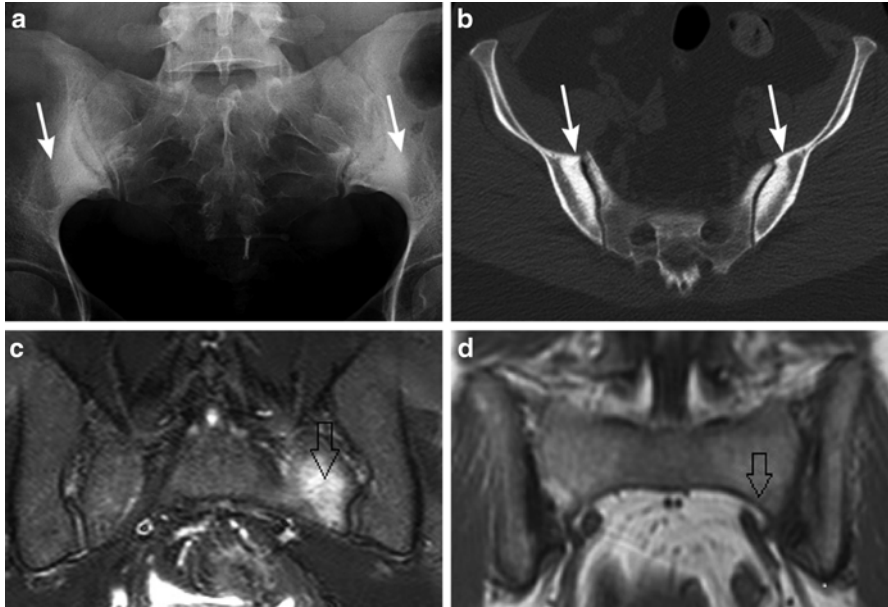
A 36-year-old woman presenting with left back pain 3 months after fifth delivery. She has a history of similar pain after other deliveries. Images taken at 3 months postpartum demonstrate the radiography (a) and CT (b) appearance of osteitis condensans ilii, an older descriptive radiographic term referring to bilateral, symmetrical, dense bone formation (arrows) in a triangular pattern along the anterior-inferior iliac side of the SI joint. Osteitis condensans ilii is associated with previous and recent pregnancies. On the MRI of the sacroiliac joints with (c) axial T2 fat saturated sequence there is an unsuspected small sacral stress fracture (arrow) in the left sacral ala with matching dark line (arrow) on the (d) axial T1 sequence
